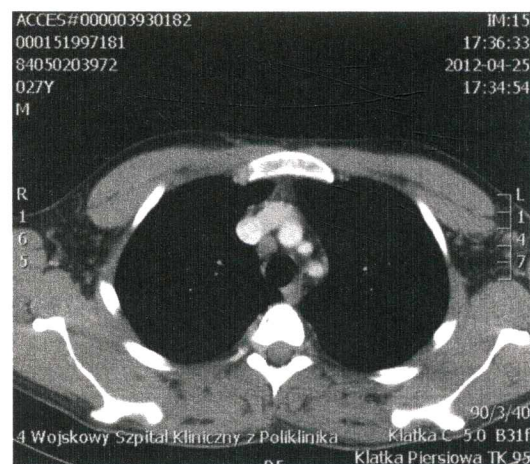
CT scan showing an enlarged right upper paratracheal lymph node (station 2R)
